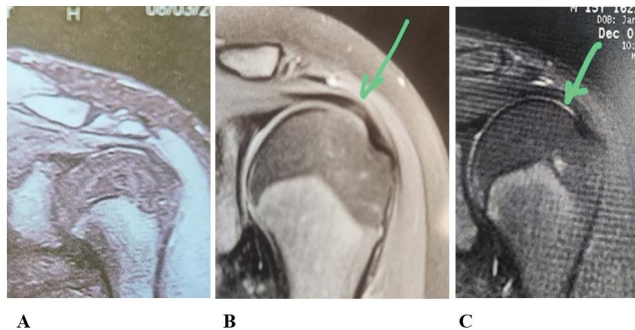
MRI showing Spoon lesion with ballooning of the supraspinatus according to our assessment causing superior instability and therapy resistant secondary impingement needing reefing of the supraspinatus capsule tendon complex to get a dynamic fixation of the head during abduction and thus preventing the superior migration. There is no tear in the tendon, there is only elongation and redundancy causing an increase in the space between the tendon and head. The tendon may be thinned compared to its insertion to the greater tuberosity (B), present in 37 cases (67%) or has the same width to its insertion to the greater tuberosity as present in 18 cases (33%) (C).
